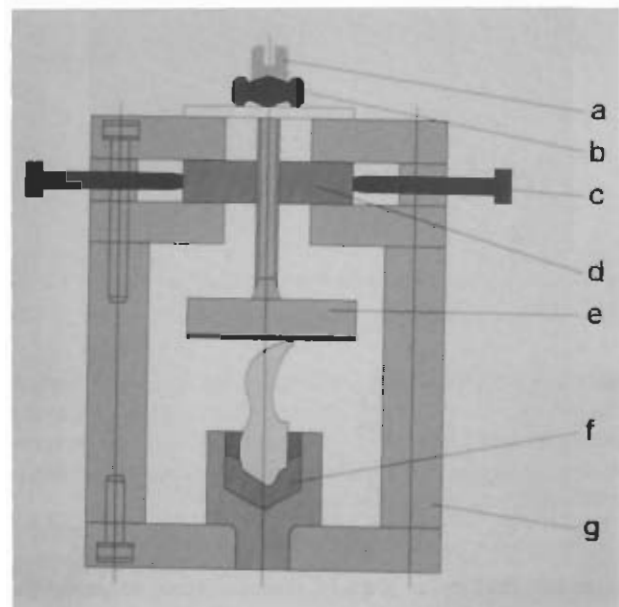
Positioning device. a, threaded pin; b, fixing nut; c, threaded pins to regulate the piston e; d, mobile plate which can be displaced transversely; e, piston; f, bushing; and g, spacing bars for mounting the positioner and fixing the X-ray films.
